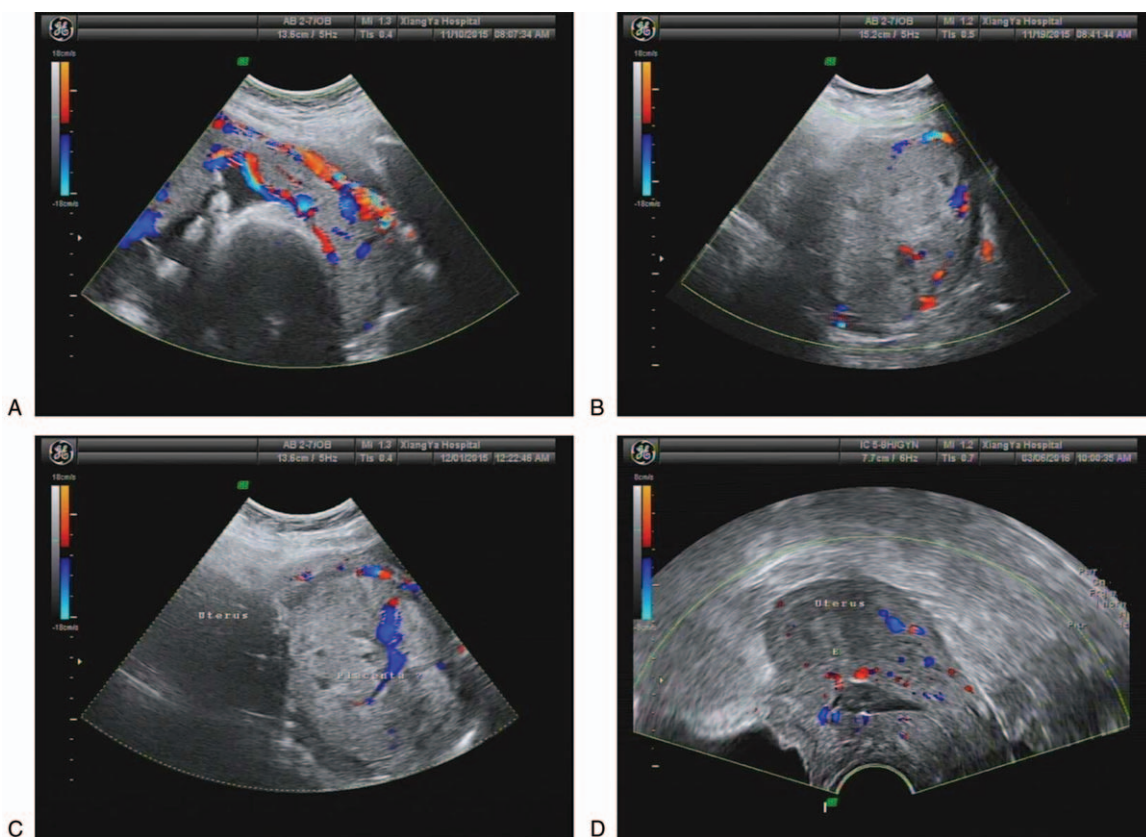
Color Doppler ultrasound images before and after cesarean section or curettage of case 3. (A) Color Doppler ultrasound images before cesarean section. (B) Color Doppler ultrasound images 5 days after cesarean section, (C) Color Doppler ultrasound images 4 days after curettage. (D) Color Doppler ultrasound images 33 days after curettage.
